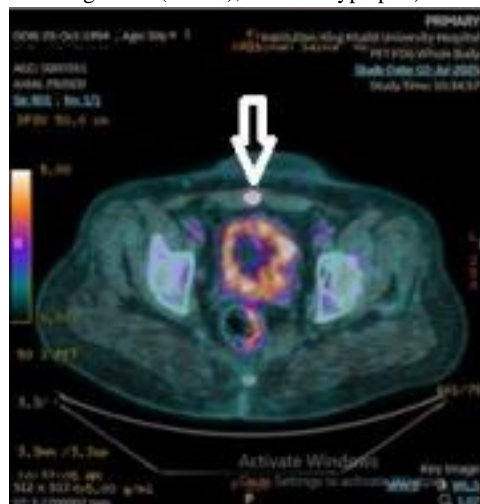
Axial FDG-PET/CT showing a focally hypermetabolic lesion in the left rectus abdominis muscle, consistent with active disease involvement.
